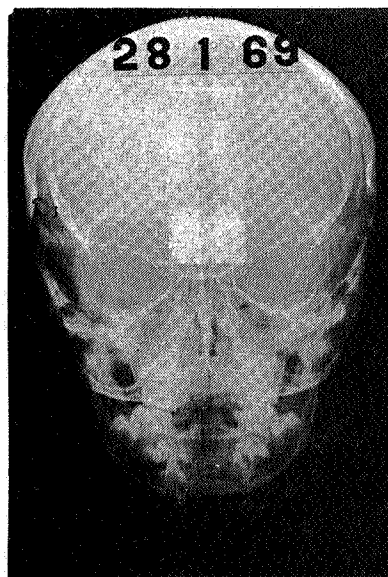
Palate Expansion — pre expansion X-ray. N.P. aged 6.
